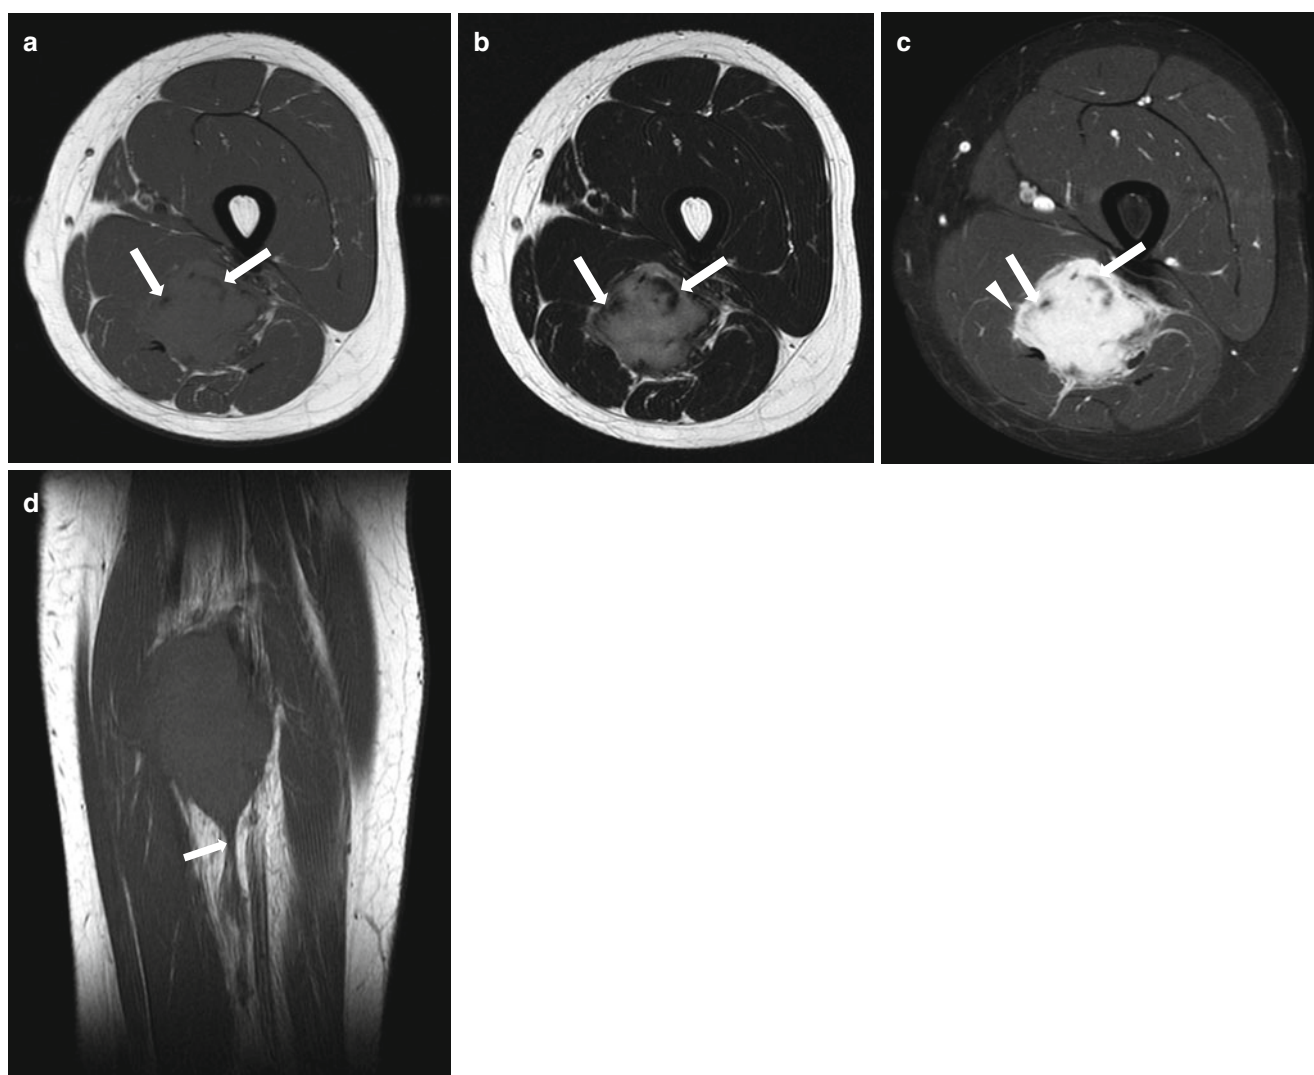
MR images of a 12-year-old boy who sustained desmoid-type fibromatosis in the thigh. Three MR images at the same level (a, b, c) show a mass with lobulating border in posterior compartment of thigh. Axial T1-weighted (a) and axial T2-weighted (b) MR images show low signal intensity foci (*arrow*), which are more prominent on T2-weighted image. (c) Axial gadolinium-enhanced fat-suppressed
